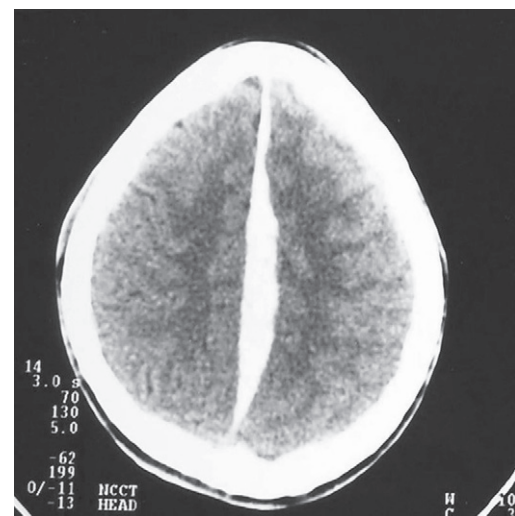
CT showing ISDH involving the entire falx
